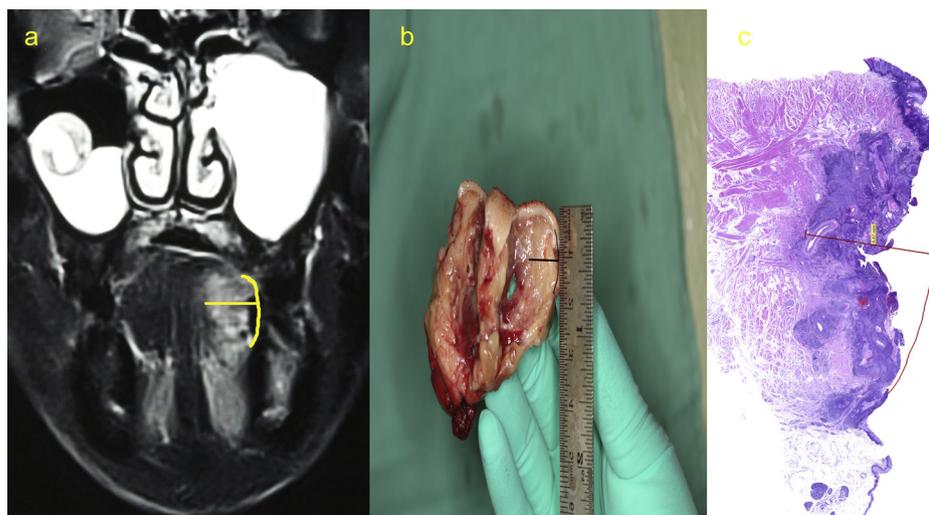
Measurement of invasion depth on MRI (a), intraoperatively (b) and pathologically (c). Measurement of the DOI based on the adjacent normal mucosal junction to the deepest infiltration point.
